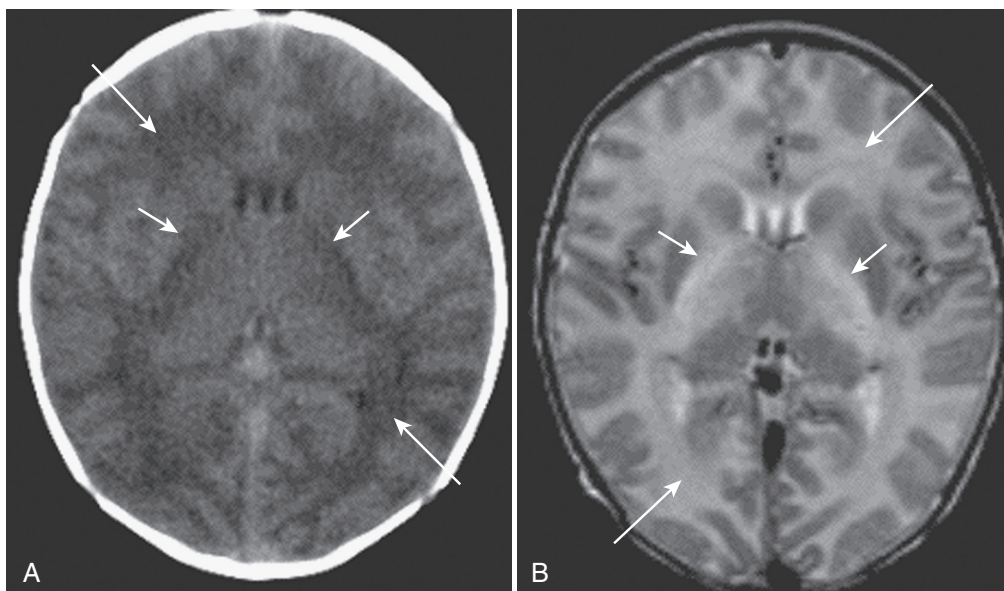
Infantile leukoencephalopathy (*arrows*) with macrocephaly on axial FLAIR MR image.
